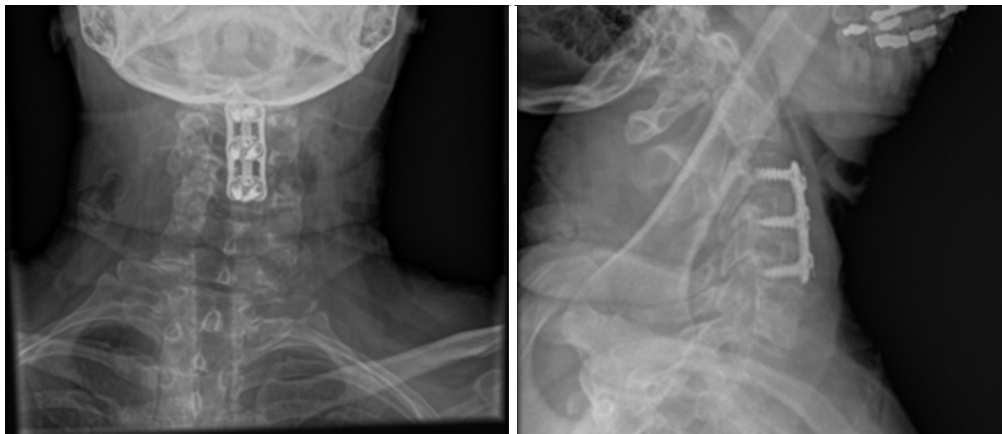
Postoperative radiographs consistent with 2 level anterior cervical decompression and fusion.
